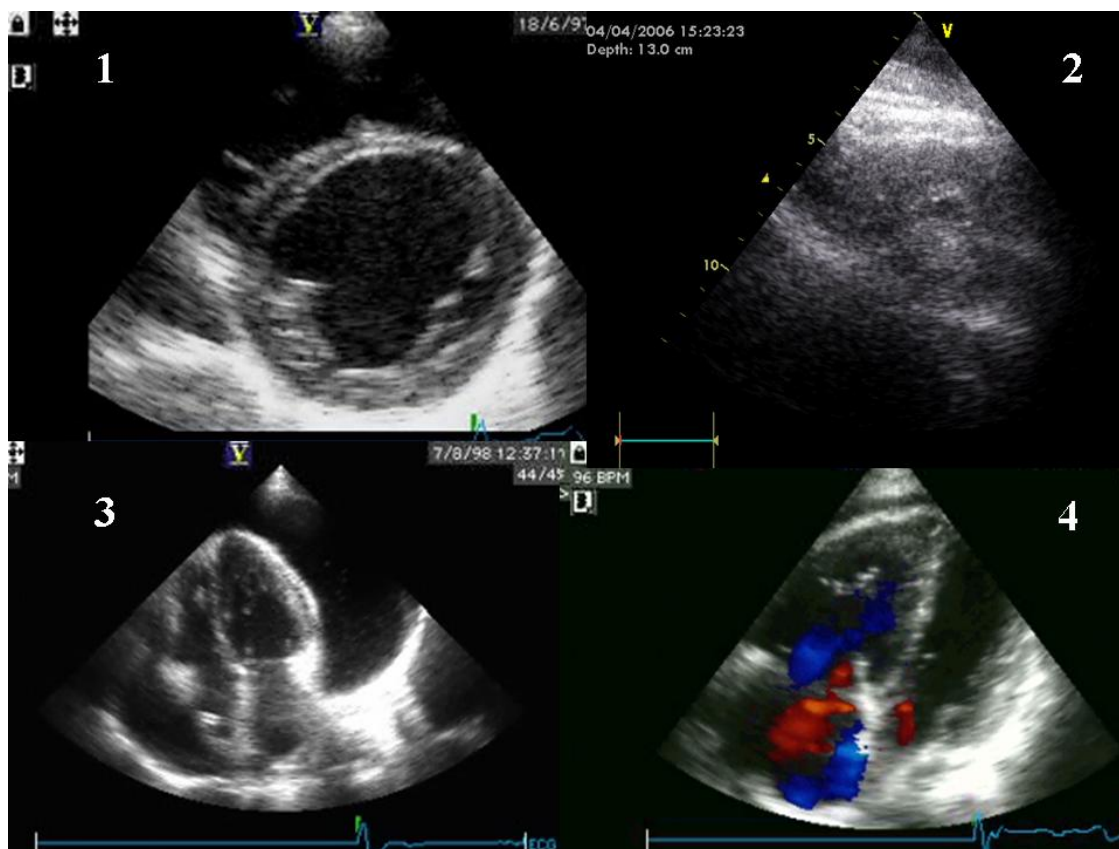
Figure showing the four most important causes of shock. 1) dilated and dysfunctional left ventricle, 2) severe left ventricular hypovolemia (poor but sufficiently image quality in an emergency case), 3) pericardial effusion and right ventricle pressure overload (pulmonary embolus). These cases are extremely difficult to differentiate between but very easy to recognise echocardiographically.
